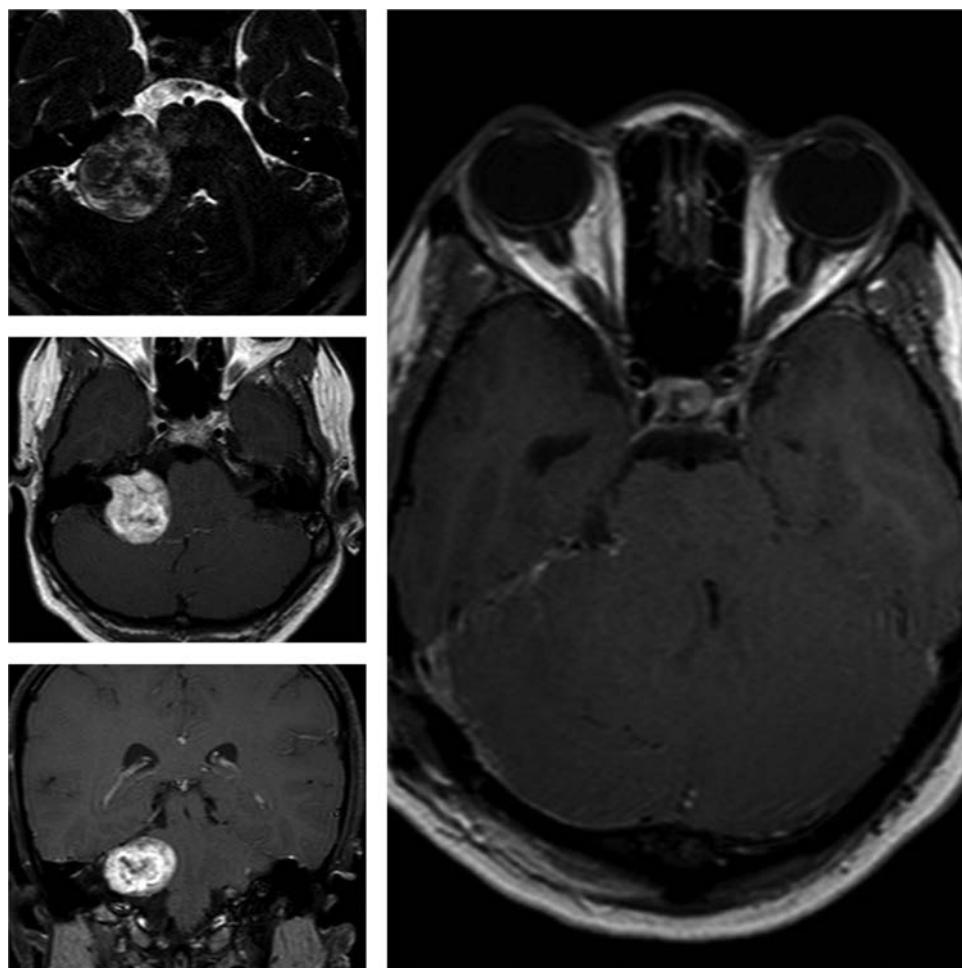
Large vestibular schwannoma compressing the trigeminal nerve. Postoperative magnetic resonance imaging.
